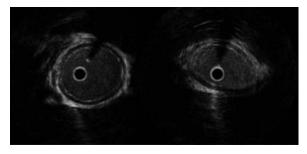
Intravascular ultrasound (IVUS) of the popliteal artery showing compression on the right with dynamic maneuvers.
